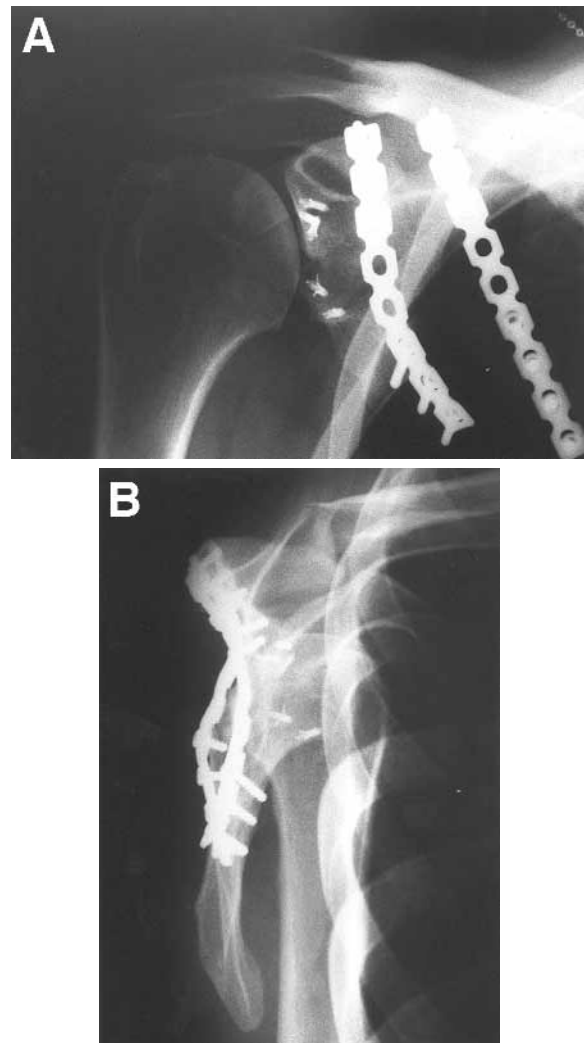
Postoperative radiographs showing the placement of reconstruction plates and bone anchors. A, True anteroposterior view. B, Lateral view.
